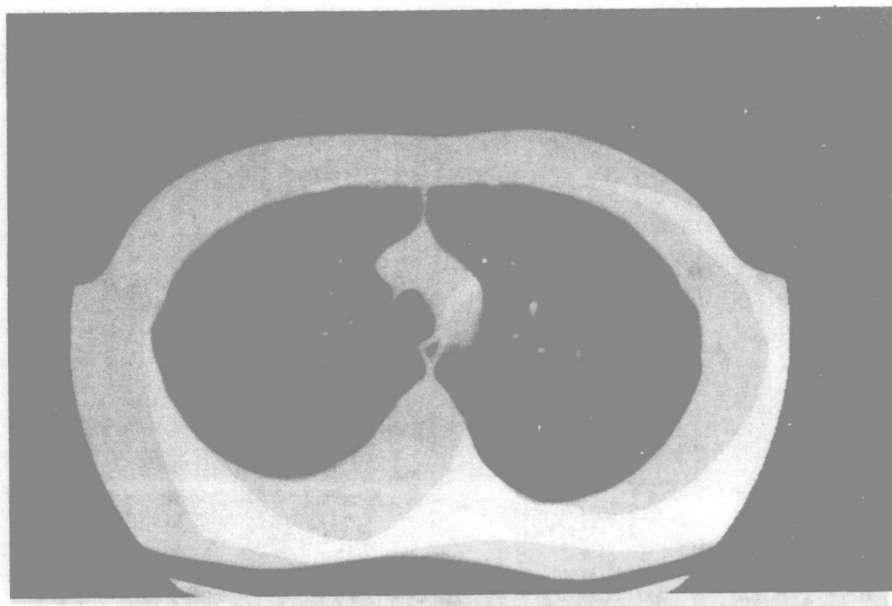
Example of Original CT Image
